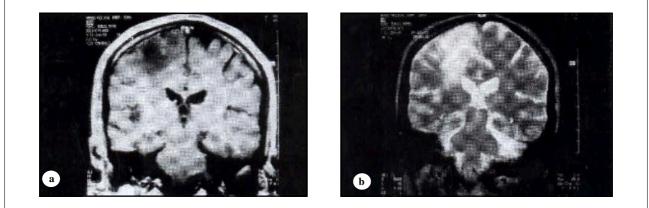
Magnetic resonance imaging (MRI) of the brain, coronal view, T1 and T2. (a) T1 is showing low signal intensity lesion in the right fronto-parietal region with no mass effect. (b) T2 post contrast showing homogenous bright signal in the same region with no enhancement.
